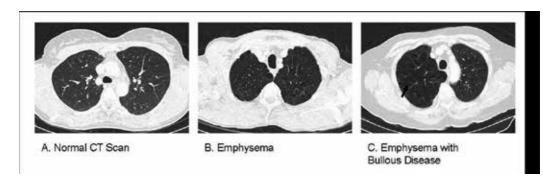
Chest high resolution CT scan of COPD. A) A single slice from a high resolution CT (HRCT) scan of thorax demonstrating normal healthy lung parenchyma. B) A single HRCT thorax image of the upper lobes demonstrating loss of lung density in keeping with emphysematous change. C) Severe emphysema of the upper lobes showing markedly reduced lung density and bullous disease present (indicated by the arrow).
